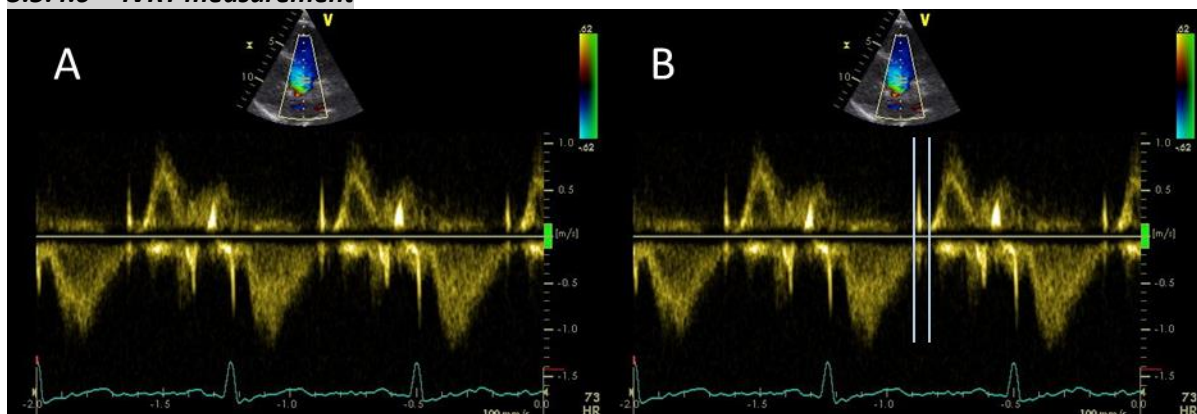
PW Doppler LVOT/MV (IVRT determination) (A) and IVRT measurement (B)
